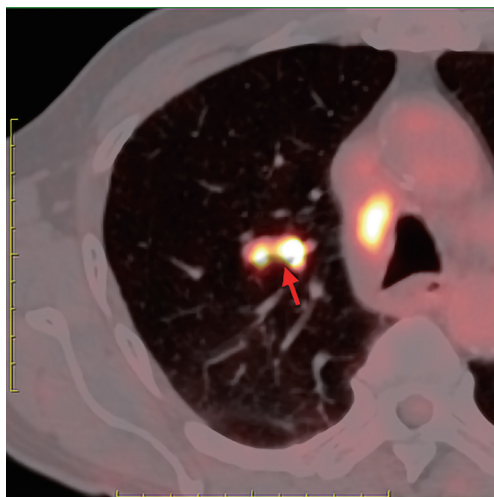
PET-CT: a nodule at the opening of the apical segmental bronchus of the upper lobe of the right lung. Maximum standard uptake value (SUV) was 8.7. (Arrow) Enlarged lymph nodes were observed in the mediastinum (4R), with significantly increased FDG metabolism and a size of approximately 1.44×2.93 cm, with a maximum SUV of 7.3.
